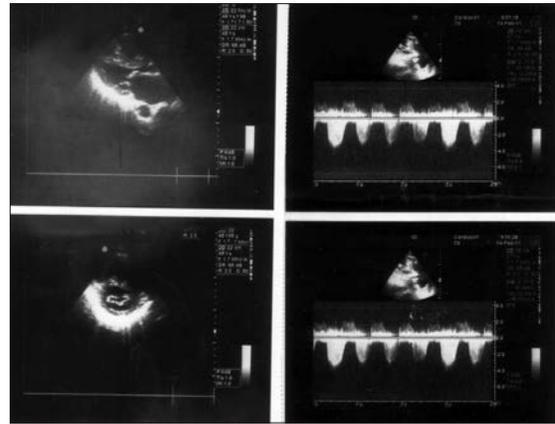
Echocardiogram. B-mode and doppler study reveal moderate MS and moderate pulmonary hypertension
